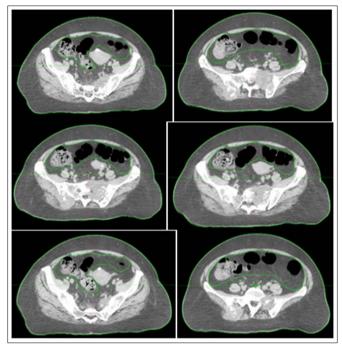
CT of Sacral Bone Metastasis
